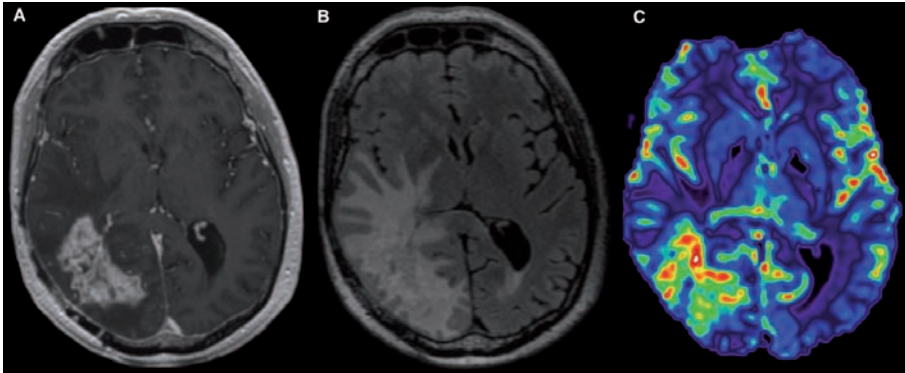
(A) Example of a recurrent glioblastoma with enhancement on the T1-weighted post-contrast image, (B) surrounding non-enhancing abnormalities on the FLAIR-image and (C) a DSC-perfusion-derived standardized and leakage-corrected rCBV map depicting increased rCBV in the enhancing tumor area.
